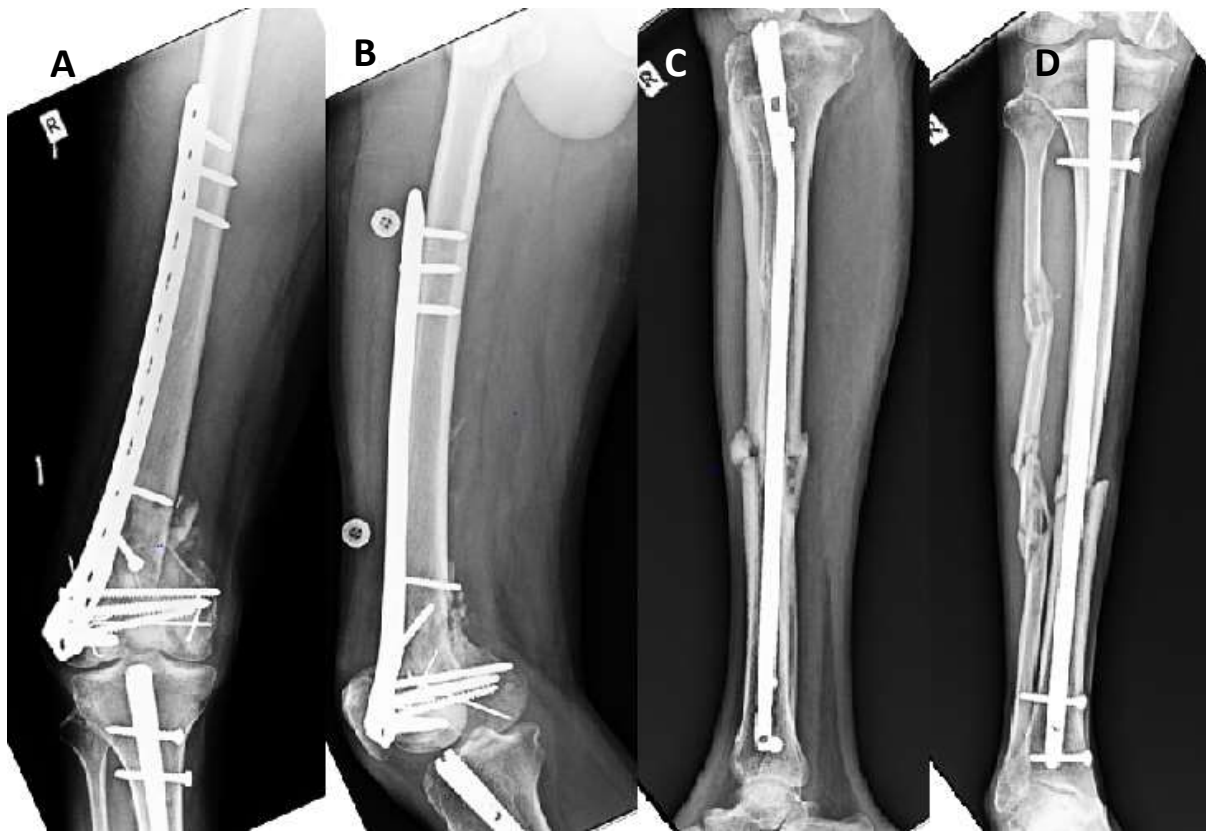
3 months post-operative radiographs showing; A and B: Antero-posterior and lateral views of distal shaft femur fracture managed with lateral condylar buttressing plate with varus collapse at the fracture site; C and D: Lateral and antero-posterior views of leg with midshaft tibia fracture managed with intra-medullary nail with signs of union
